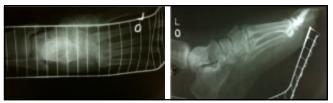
Anteroposterior and Lateral Radiograph Showing Disruption of the Lisfranc Complex
